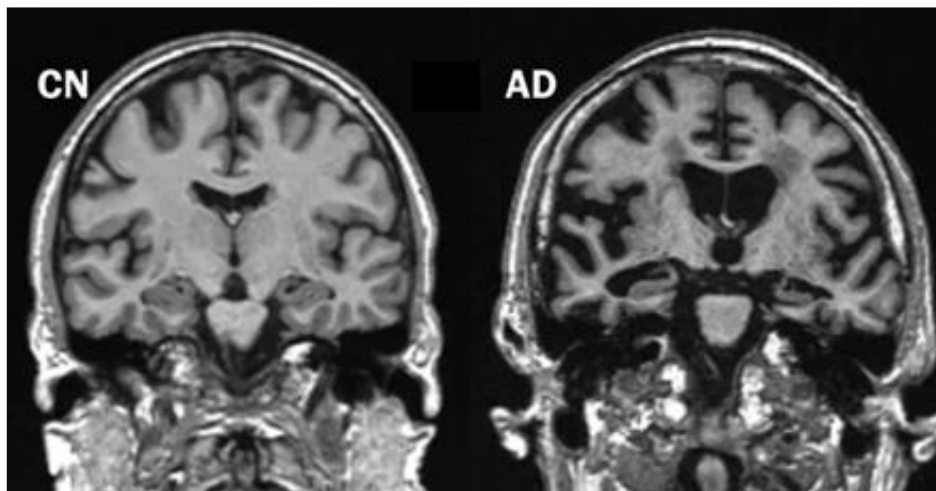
Magnetic resonance imaging (MRI) scan. Coronal section from a cognitive normal (CN) and an Alzheimer's disease (AD) subjects. Modified figure from [10].
